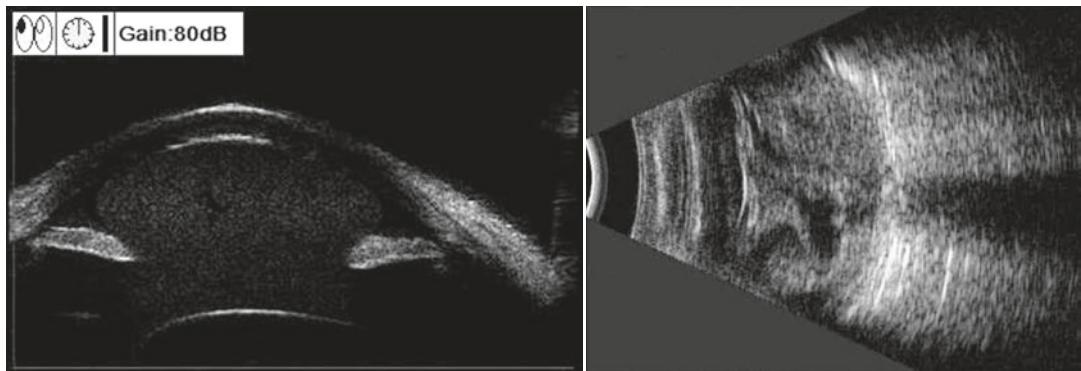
UBM images demonstrated the hyphema and lens subluxation (*left*). B ultrasound showed vitreous hemorrhage without retinal detachment (*right*)
